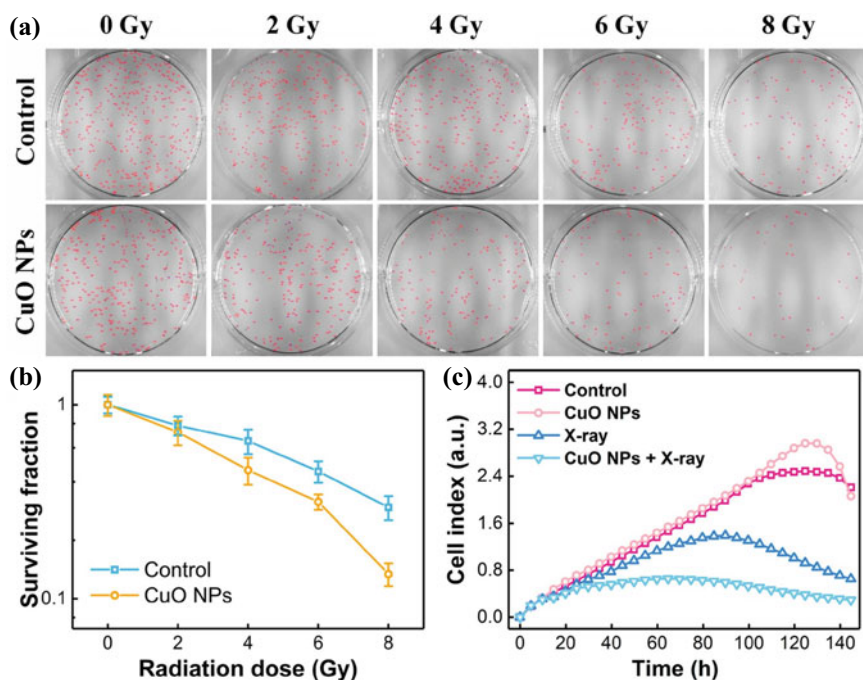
Radiosensitization evaluation for CuO NPs. a Photographs of colonies formed by MCF-7 cells exposed to X-rays and treated with either CuO NPs or without b cell surviving fractions of the samples c Growth results of MCF-7 cells after different treatments as indicated. Reproduced with the permission from [109]
